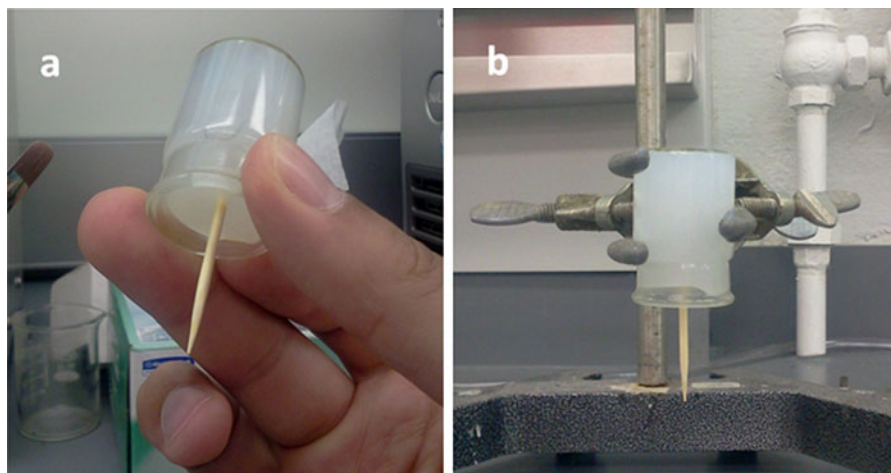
TEMPO-oxidized MCC gel (3.88 wt%) following the ultrasonic dispersion
